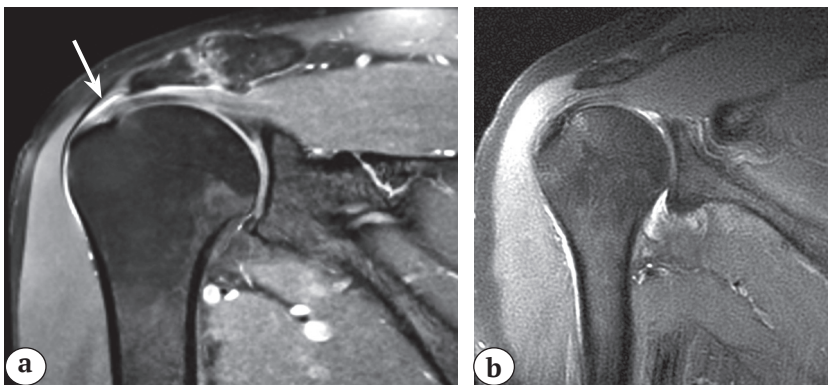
Changes in the structure of supraspinatus tendon on MRI (indicated by arrow) (PD FS TSE mode, FOV – 120 mm, section thickness 3.0 mm):
